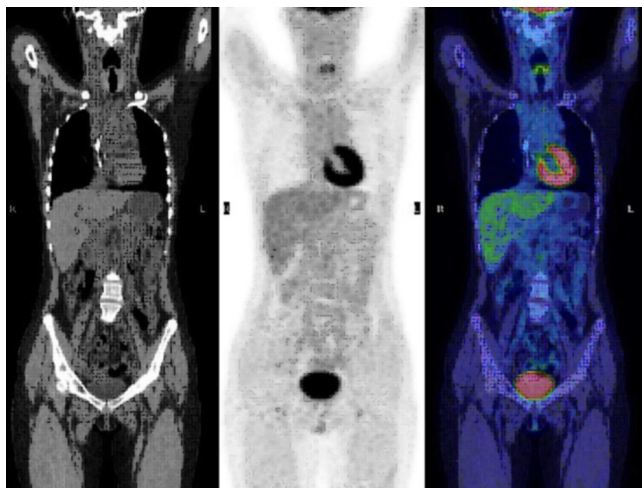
14-year-old girl with nonossifying fibroma. Coronally reformatted CT (left), coronal F18-FDG PET (middle), and F18-FDG PET/CT fusion image (right). The lymphadenopathy noted in Figure 1 has completely resolved.
